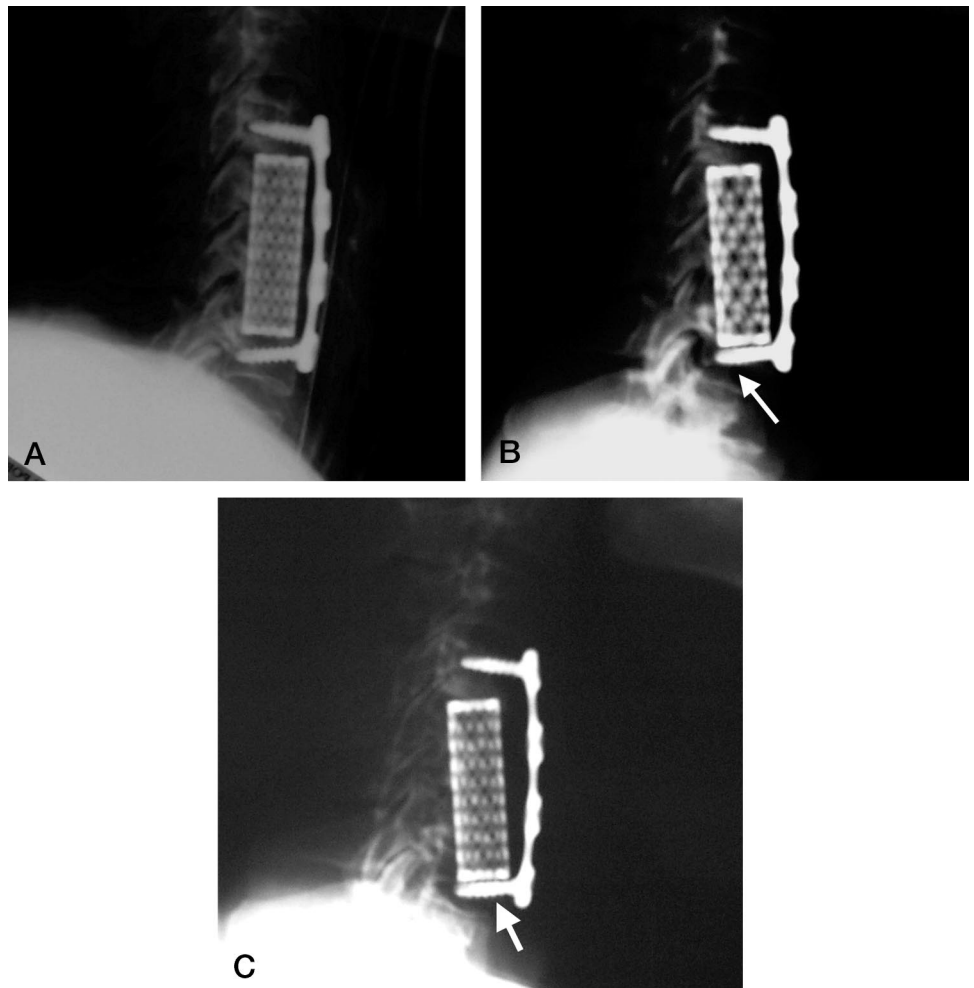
A 62-year-old female who underwent a 2-level corpectomy of C5 and C6 with fusion from C4–C7. A, Postoperative lateral radiograph at 2 weeks. B, Postoperative lateral radiograph at 6 weeks showing subsidence of the cage into the C-7 vertebral body. C, Postoperative lateral radiograph at 10 weeks showing complete subsidence of the cage through the endplate of C-7 into the disc space of C7–T1.
